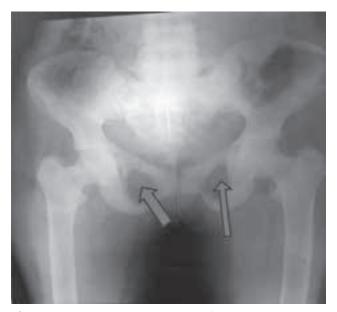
X-ray pelvis shows pseudo-fracture.
